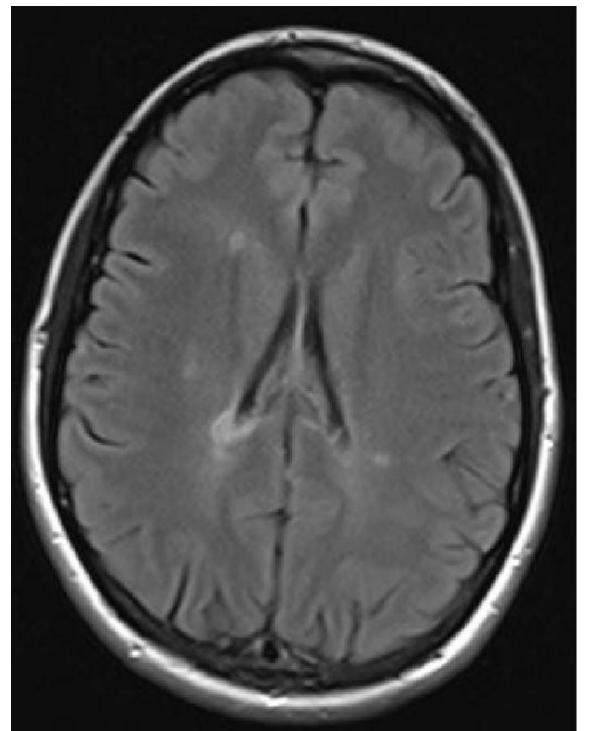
Brain and cervical spine MRI showing typical MS lesions.
